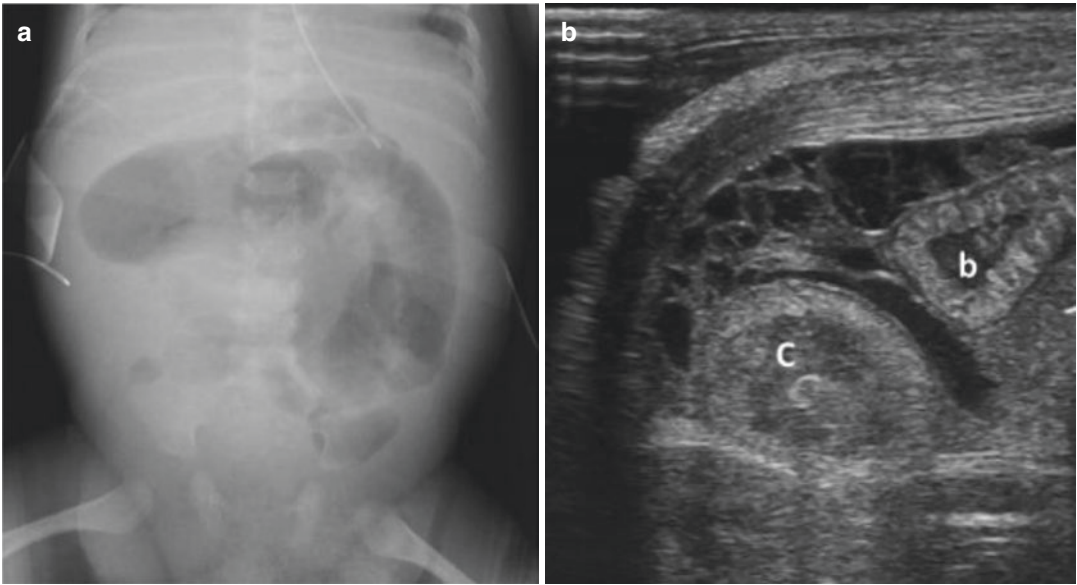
Peritonitis following perforation of NEC in a premature. (a) Plain film of the abdomen confirming bowel (sub)obstruction and probable effusion. (b) US—Transverse scan—Septated collection in the right flank
